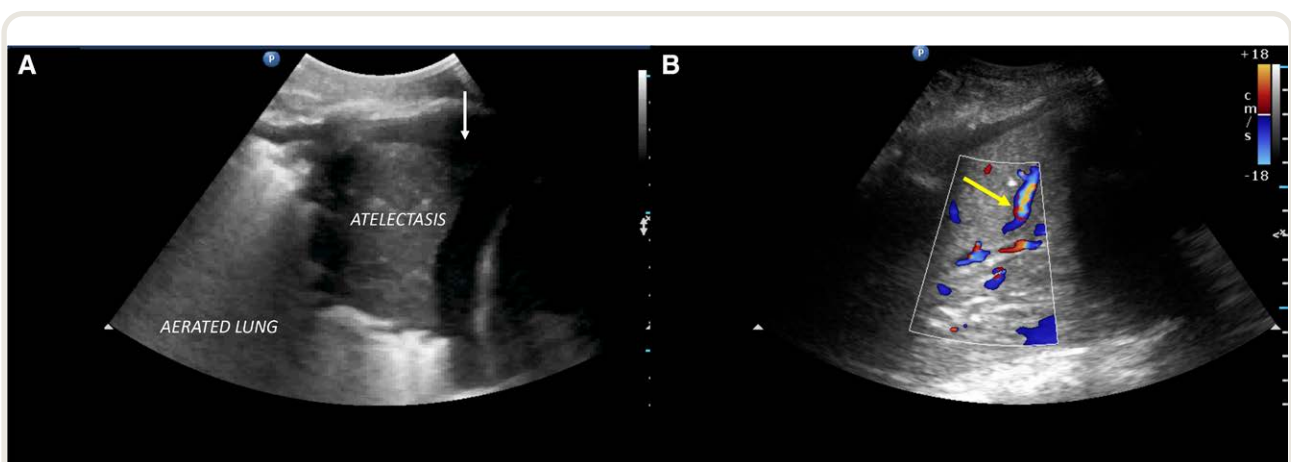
Detection of pulmonary atelectasis by ultrasound. (A) Pulmonary atelectasis revealed by a pulmonary consolidation surrounded by a pleural effusion (white arrow). (B) Color Doppler imaging showing the persisting pulmonary blood flow within consolidated lung (yellow arrow) due to incomplete hypoxic pulmonary vasoconstriction, which may result in a shunt effect.
